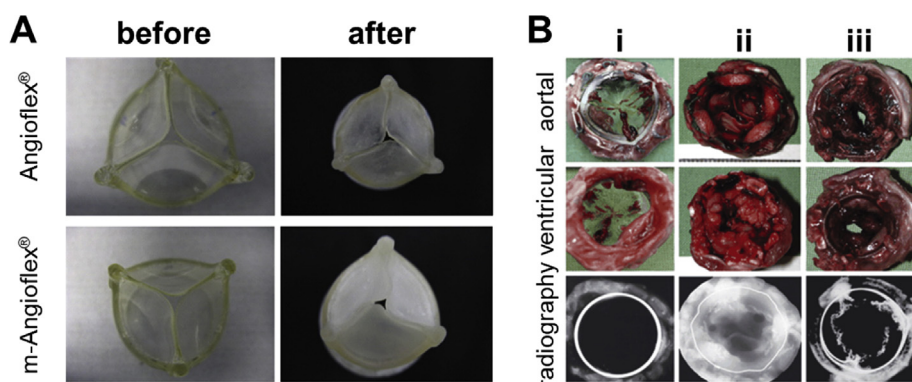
Angioflex® and bisphosphonate-modified Angioflex® (polyether-based polyurethane) valves before and after calcification (A) [79]. Further examination revealed that the nature of calcification differs between the two materials. (B) Polycarbonate urethane heart valves after 20 weeks of implantation (i) compared with Mosaic® after 10 days (ii) and Perimount® after 30 days (iii) [82]. No visible calcification could be detected for polycarbonate urethane in radiography compared to Mosaic® and Perimount® samples.
